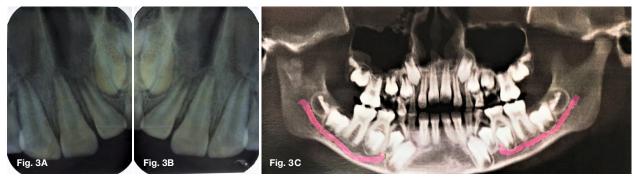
Case 1 - Pretreatment radiographs: A. IOPA of left central and lateral incisors. B. IOPA of right central and lateral incisors. C. OPG.
